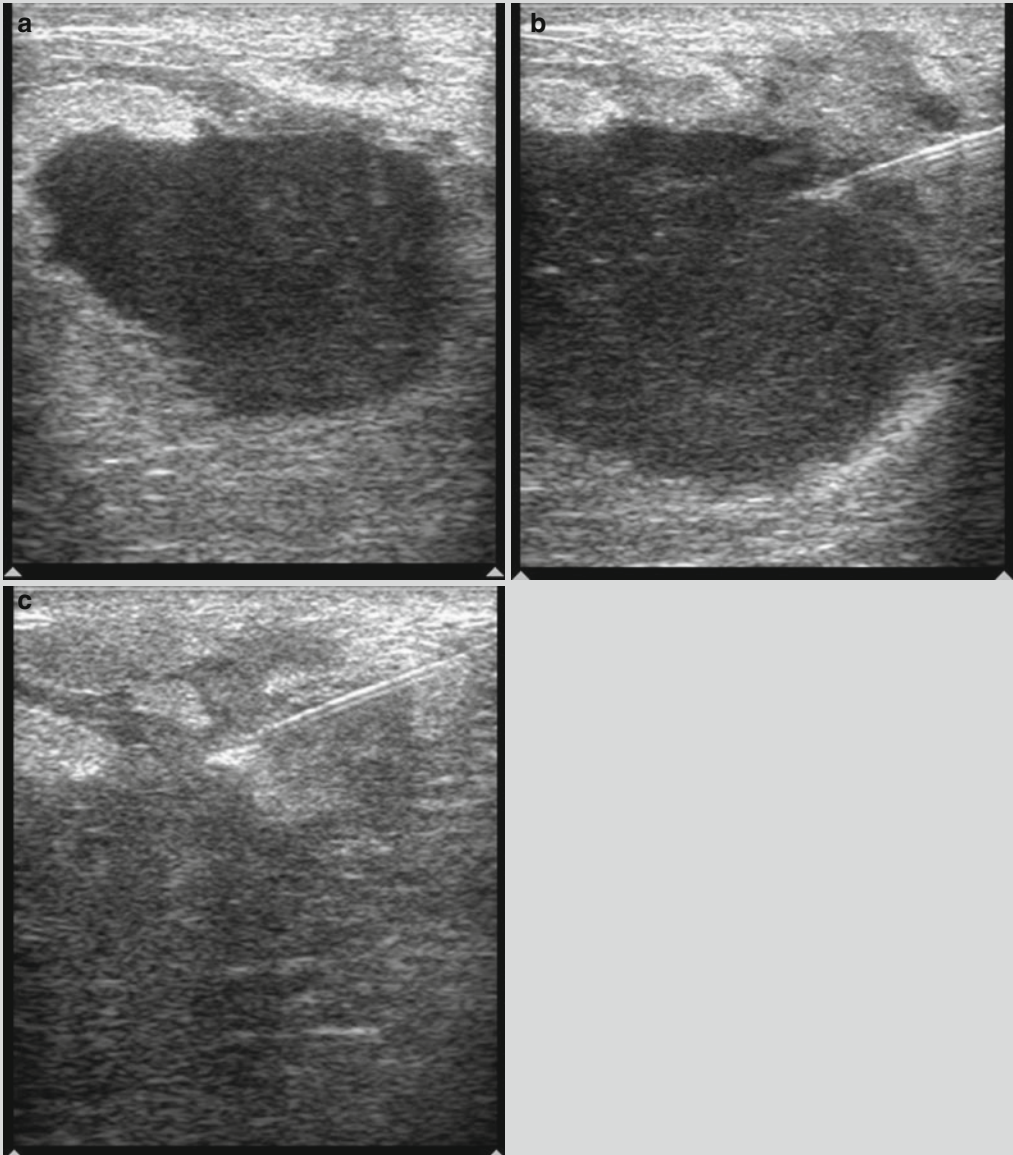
(a) Ultrasound of lactating breast abscess. (b) Ultrasound of lactating breast abscess with needle in abscess. (c) Ultrasound of lactating breast abscess post aspiration
